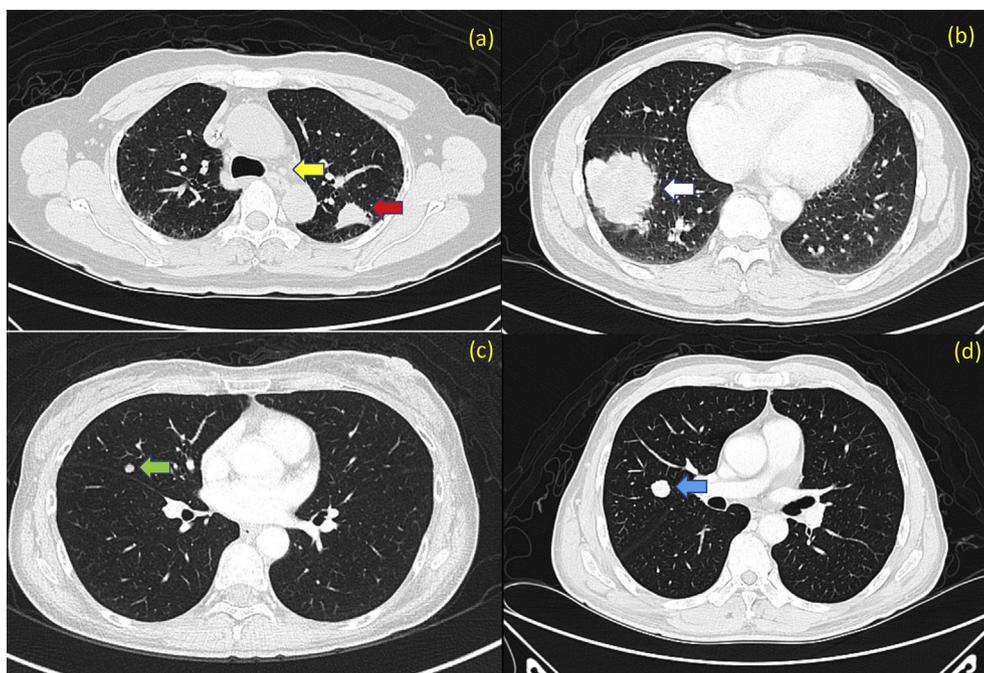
Morphology of pulmonary nodules on chest CT: (a) CSPLC patient with a single solitary nodule with irregular margin (red arrow) and enlarged mediastinal lymph node (yellow arrow). (b) CRCLM patient with a single solitary nodule with irregular margin (white arrow). (c) CRCLM patient has multiple lung nodules with smooth margin (green arrow). (d) CRCLM patient has a single solitary nodule with smooth margin (blue arrow).
